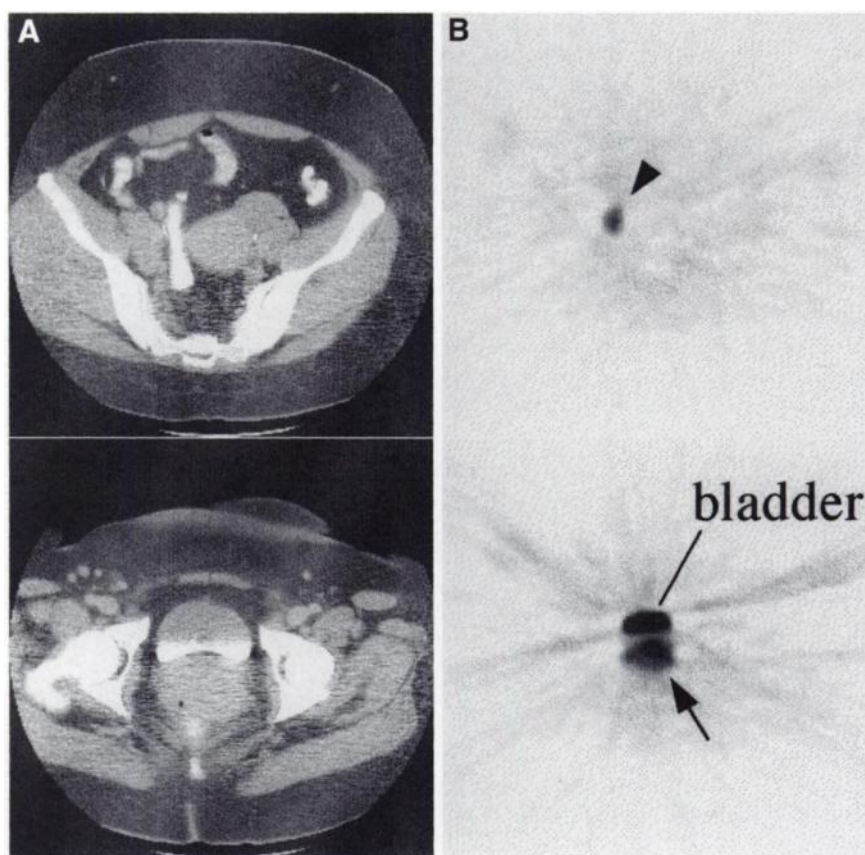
Contrast-enhanced CT images (A) and FDG PET images (B) of 33-y-old woman (patient 16) with cervical cancer and lymph node metastasis. Both primary cervical cancer (arrow) and right intrapelvic lymph node metastasis (arrow-head) show intense FDG uptake.
